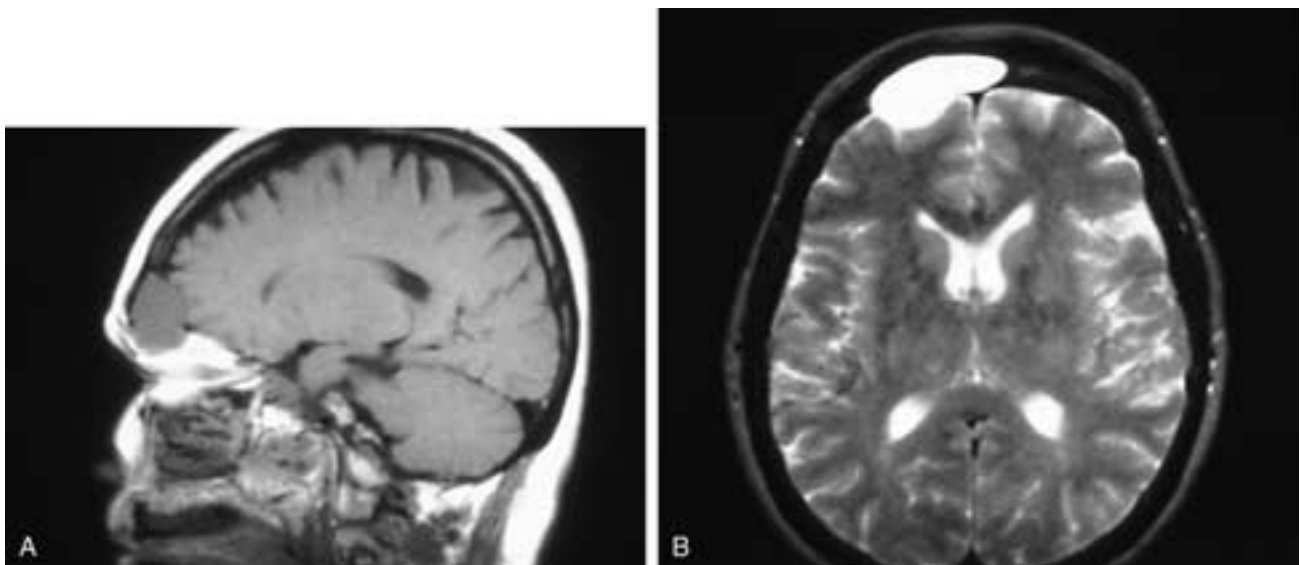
Sagittal T1-weighted (A) and axial T2-weighted (B) MR images show an expanded, airless frontal sinus filled with material that has a low T1-weighted and a high T2-weighted signal intensity. The mass extends down into the upper medial orbit. The posterior sinus wall appears eroded but is only deossified by the chronic pressure of this right frontal sinus mucocoele.
